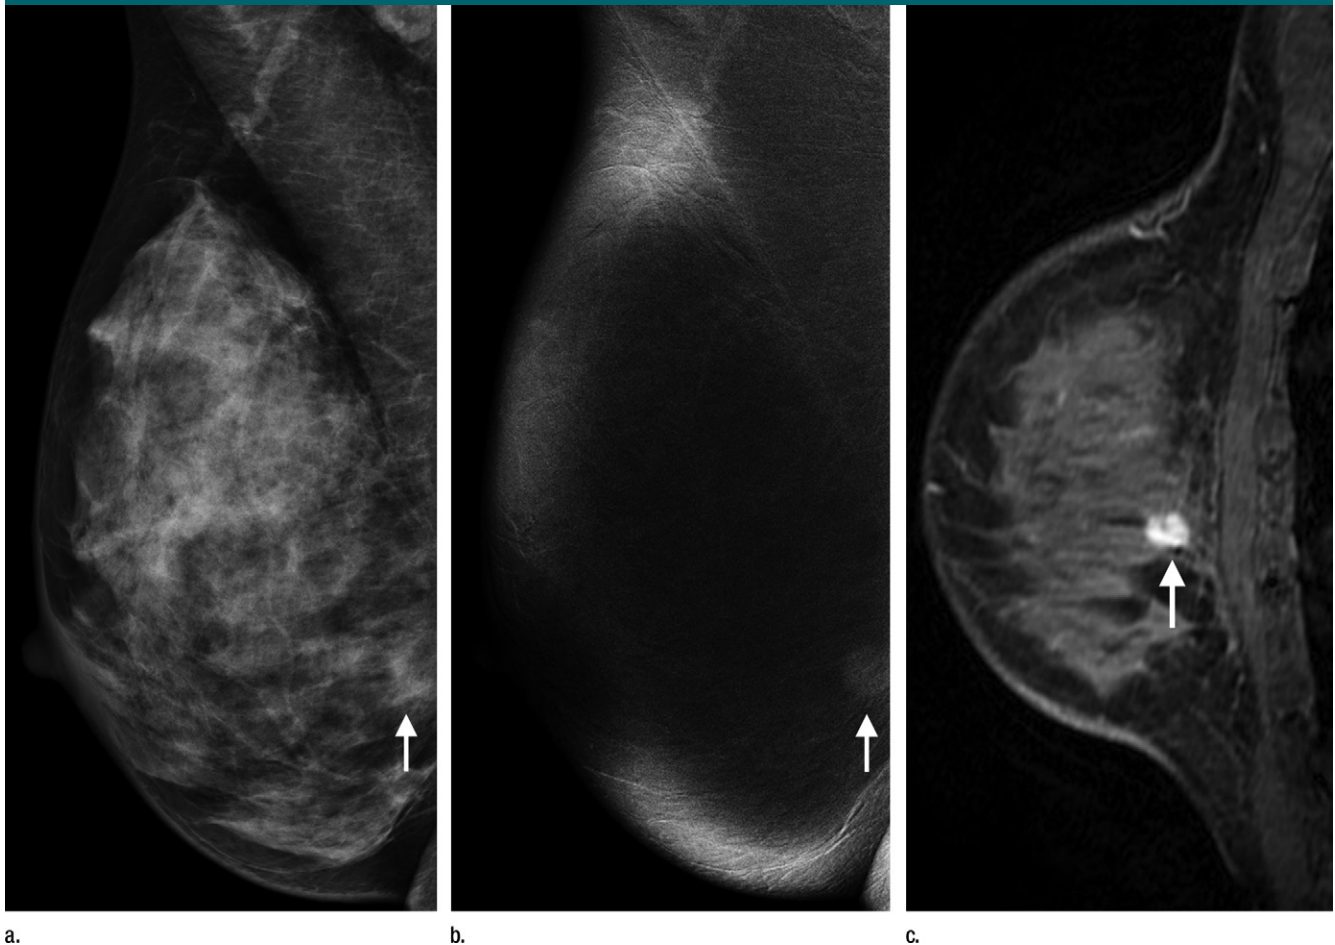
Right (a) mediolateral oblique conventional digital mammographic, (b) DE CE mammographic, and (c) sagittal MR images show infiltrating ductal carcinoma (arrows) of the right breast in 43-year-old woman.
